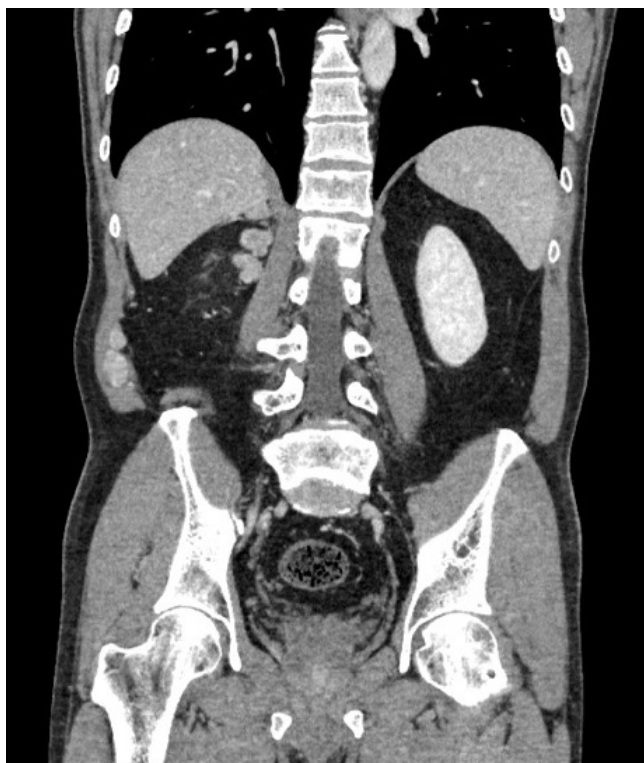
Contrast-enhanced CT abdomen (coronal plane) shows the presence of multiple homogeneously enhancing lobulated nodules at the right paranephric region as well as the right posterior-lateral abdominal wall which suggestive of metastatic nodules.
